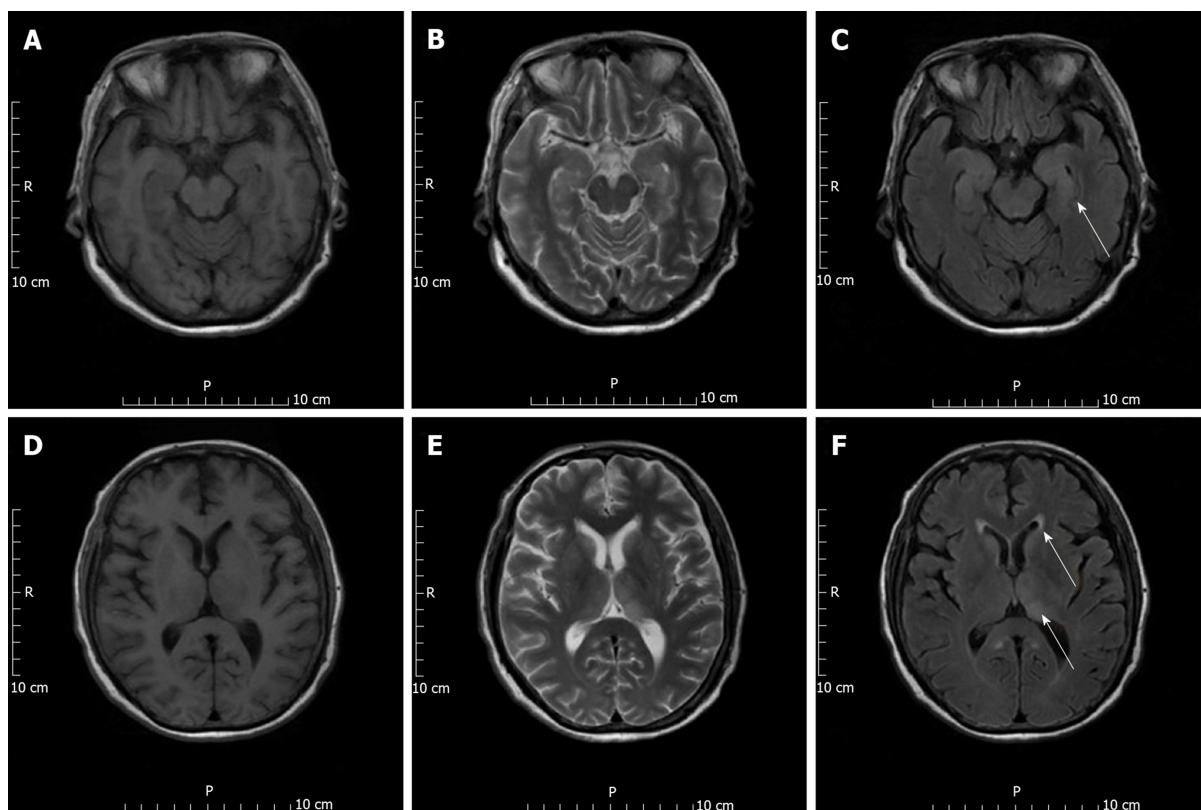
Enhanced magnetic resonance imaging scan of the patient's brain on post-transplantation day 19. A, B, D, E: Lesions can be seen in T1 image (A, D) and T2 image (B, E); C: Hyperintense lesion is seen in this T2 fluid attenuated inversion recovery image in parahippocampal gyrus; F: Hyperintense lesions are seen in this T2 fluid attenuated inversion recovery image in the bilateral thalamus and caudate nucleus. Arrows indicate the lesions.
